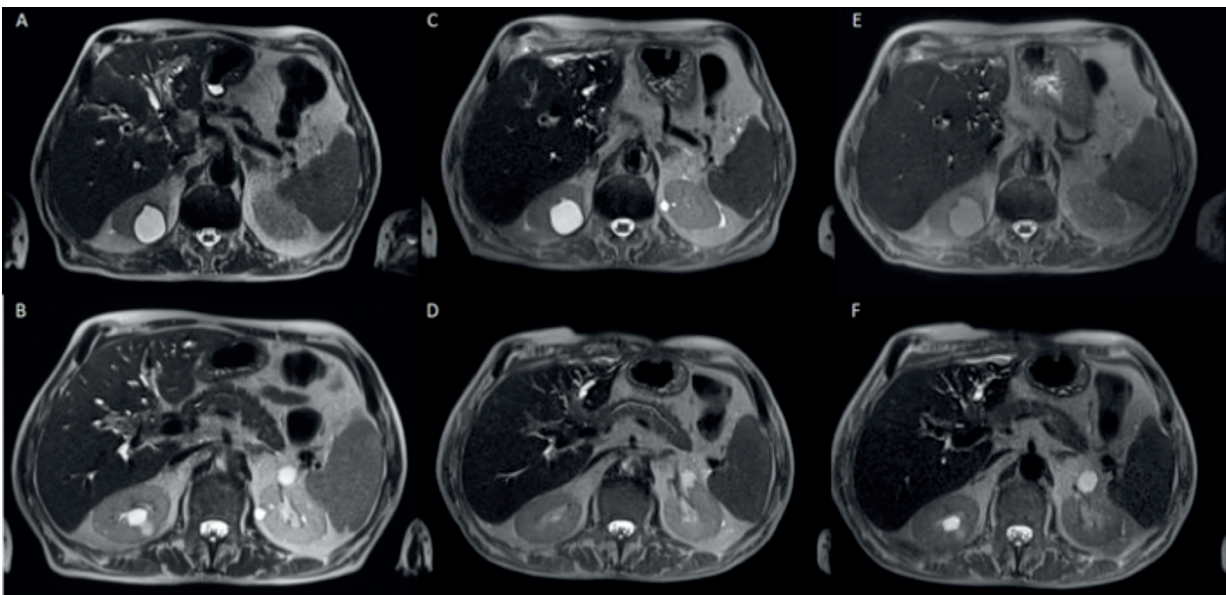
T2 weighted MR images in axial plane before (A-B), after 2 months (C-D) and after 4 months from ECT (E-F).
